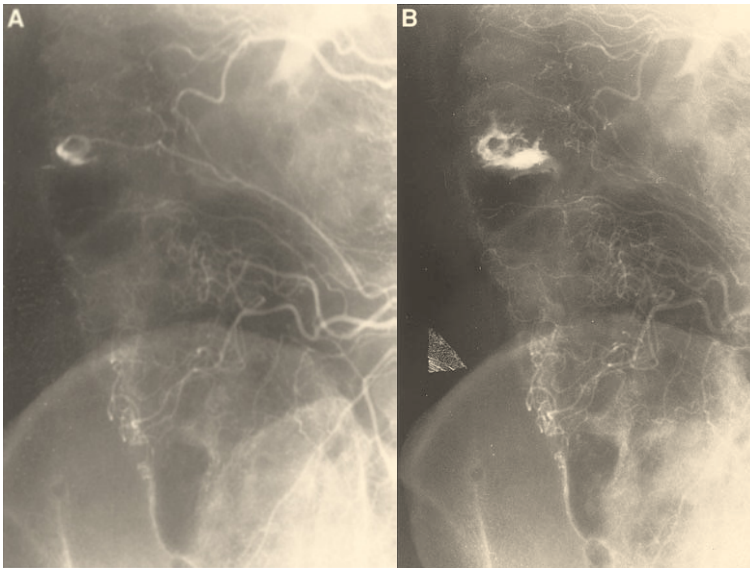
Upper mesenteric arteriogram of a patient with bleeding from the right colon diverticulum. ((A) Early X-ray vision with contrast material showing the diverticulum (top left). ((B) A late X-ray vision showing the overflow of contrast material into the lumen of the colon. (3)
